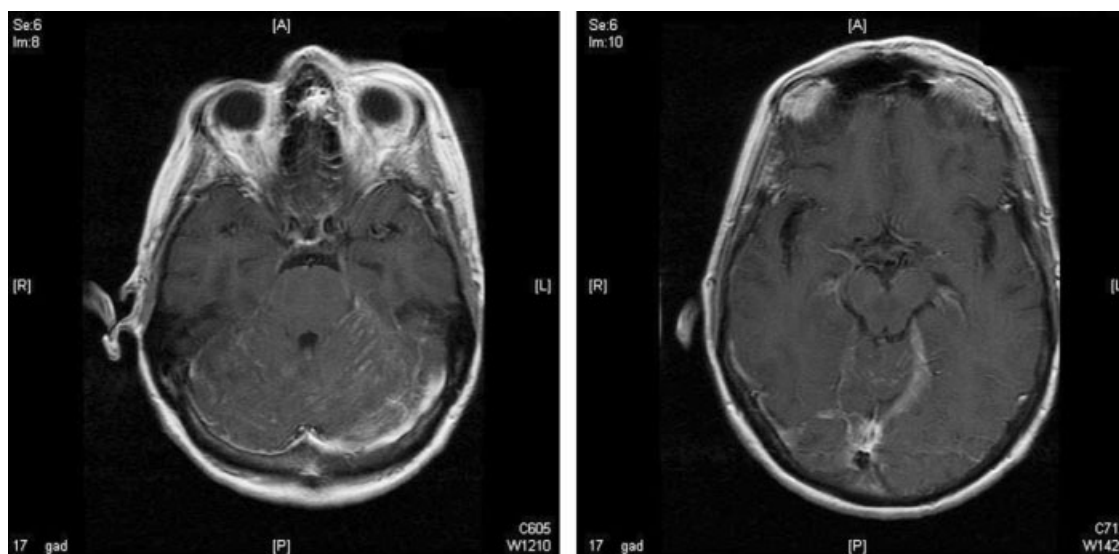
Brain MRI with contrast, showing leptomeningeal and dural enhancement in posterior fossa.
